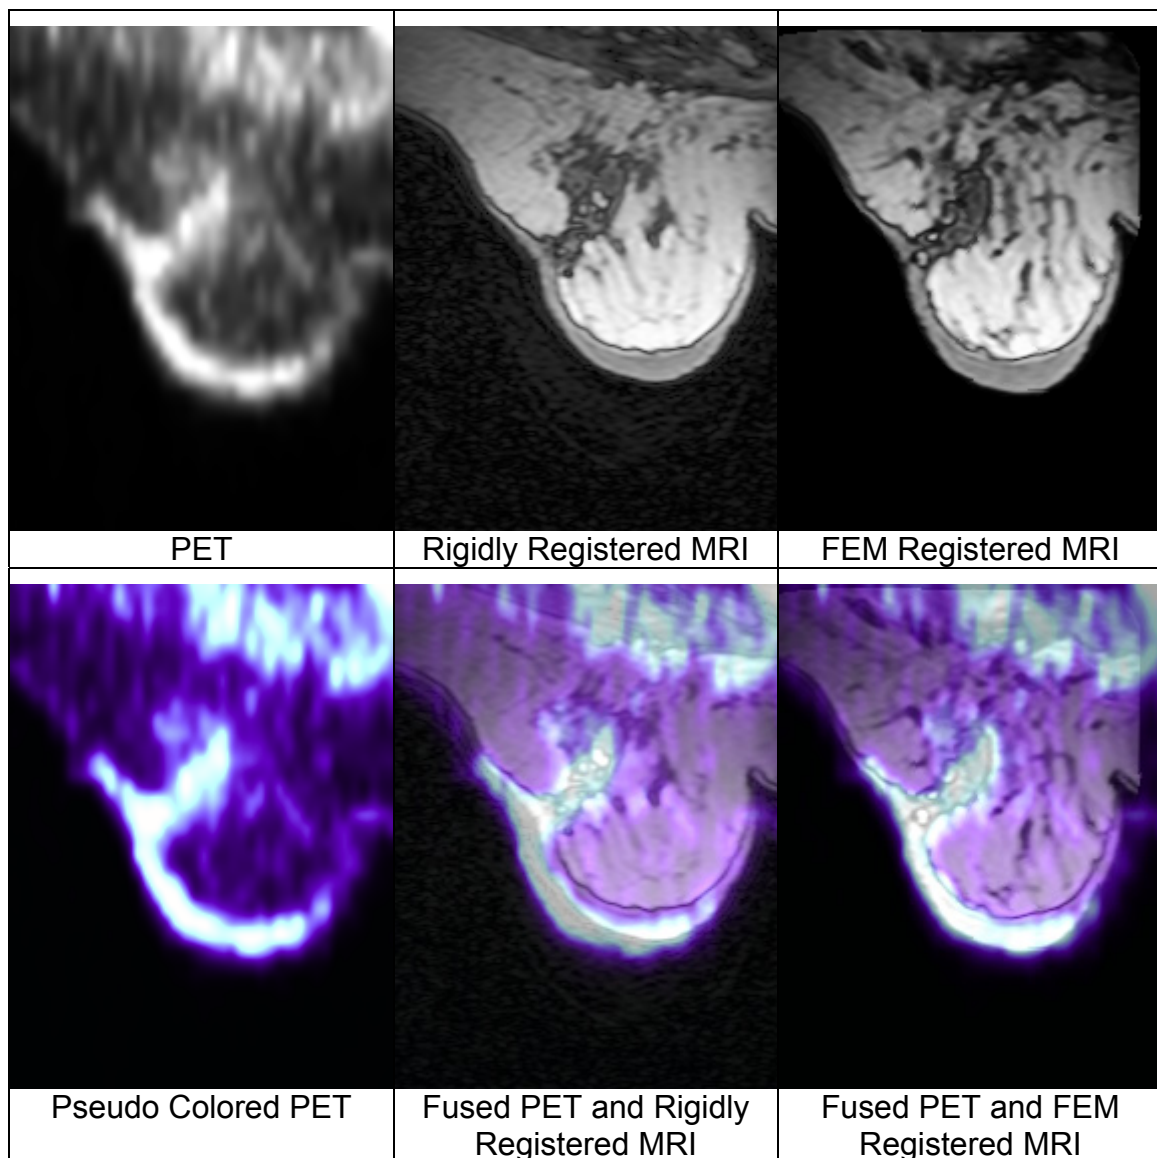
Example demonstrating the improvement of FEM registration over rigid registration. Original PET image (top left), MRI image after rigid registration (top middle), MRI image after FEM registration (top right), pseudo colored PET image (bottom left), fused pseudo color PET image and MRI image after rigid registration (bottom middle), and fused pseudo color PET image and MRI image after FEM registration (bottom right). Improvements in registration can be seen along the skin surface and at the areas of higher activity within the body of the breast. Look up tables used to pseudo color PET image and fuse MRI and PET images are shown in Figure 2.37 and Figure 2.38, respectively.
